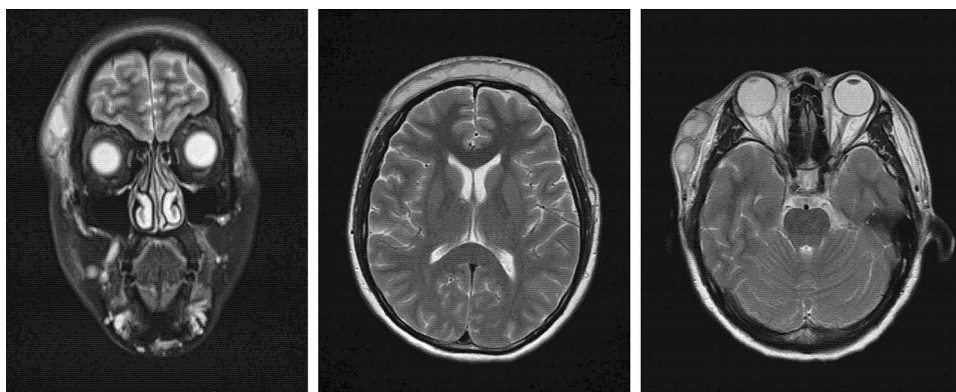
On the cranial MRI examination, multiple cystic signal shadows are visible in the subcutaneous area of the right temporal region.
